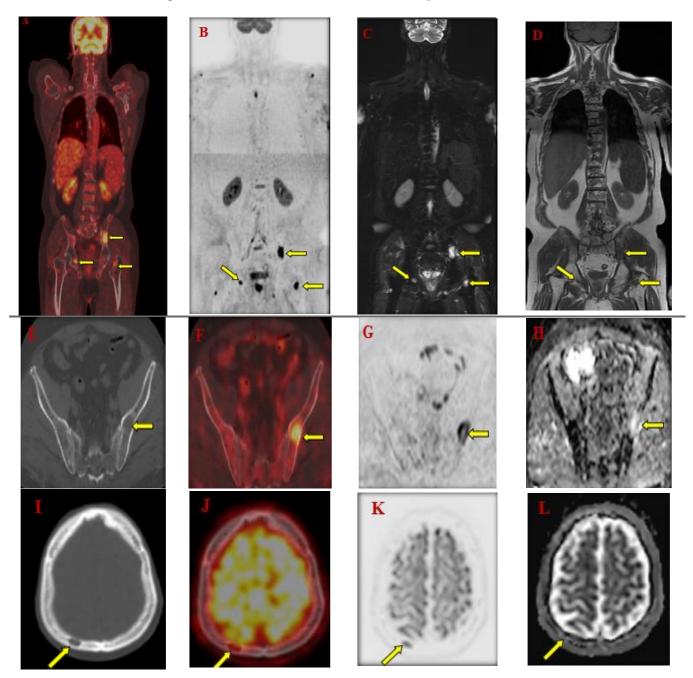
(A): PET/CT coronal images showing: multiple focal bone marrow lesions seen involving the left iliac bone, right accetabulum and both femori, displaying increased FDG uptake with SUV for example (SUV in left iliac bone = 6), (B, C and D) MRI with WBD (inverted scale), STIR, T1 WI sequences in coronal sections respectively showing: multiple focal bone marrow lesions seen involving the left iliac bone, right accetabulum and both femori, displaying low SI in TWI and high SI in STIR sequences, with restricted diffusion (high SI) in DWI, (E and F) PET/CT in axial section on the pelvis, showing lytic lesion in the left iliac bone showing increased FDG uptake (SUV = 6), (G and H) MRI-DWI (inverted scale) axial image on the pelvis showing restriction in DWI of the same lesion [Appear high SI in DWI and low SI in ADC image (ADC value = 0.85×10^{-3} mm²/sec)], (I and J) PET/CT in axial section on the skull, showing lytic lesion in the right occipital skull bone with no FDG uptake, (K and L) MRI-DWI (inverted scale) axial image on the skull showing restriction in DWI of the same lesion (Appear high SI in DWI and low SI in ADC image (ADC value = 0.62×10^{-3} mm²/sec)
